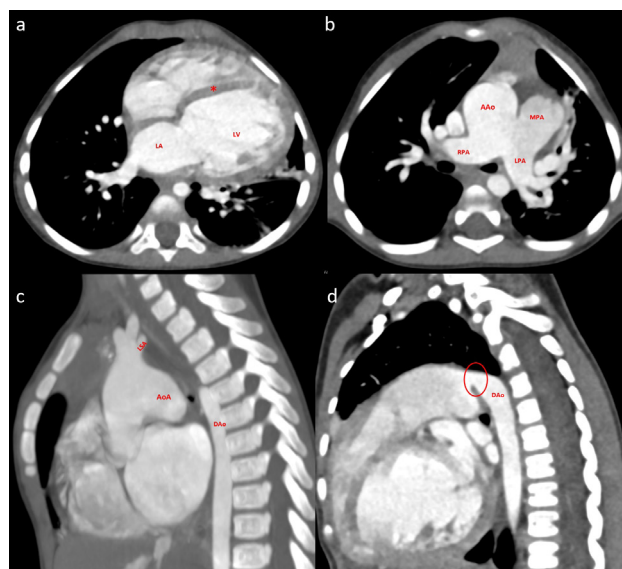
Axial thoracic CT angiography scan (a) shows cardiomegaly with dilated left heart chambers (LA, left atrium; LV, left ventricle). An intact interventricular septum is present (*). (b) shows an aortopulmonary window with the right pulmonary artery (RPA) originating from the ascending aorta (AAo) and the left pulmonary artery (LPA) originating from the main pulmonary artery (MPA), forming the characteristic “butterfly” sign. Sagittal images demonstrate a type A interrupted aortic arch (AoA), between the left subclavian artery (LSA) and the descending aorta (DAo) (c), and a patent ductus arteriosus (circle, d) continuing as the descending aorta (DAo) (d). These findings were consistent with Berry syndrome.
